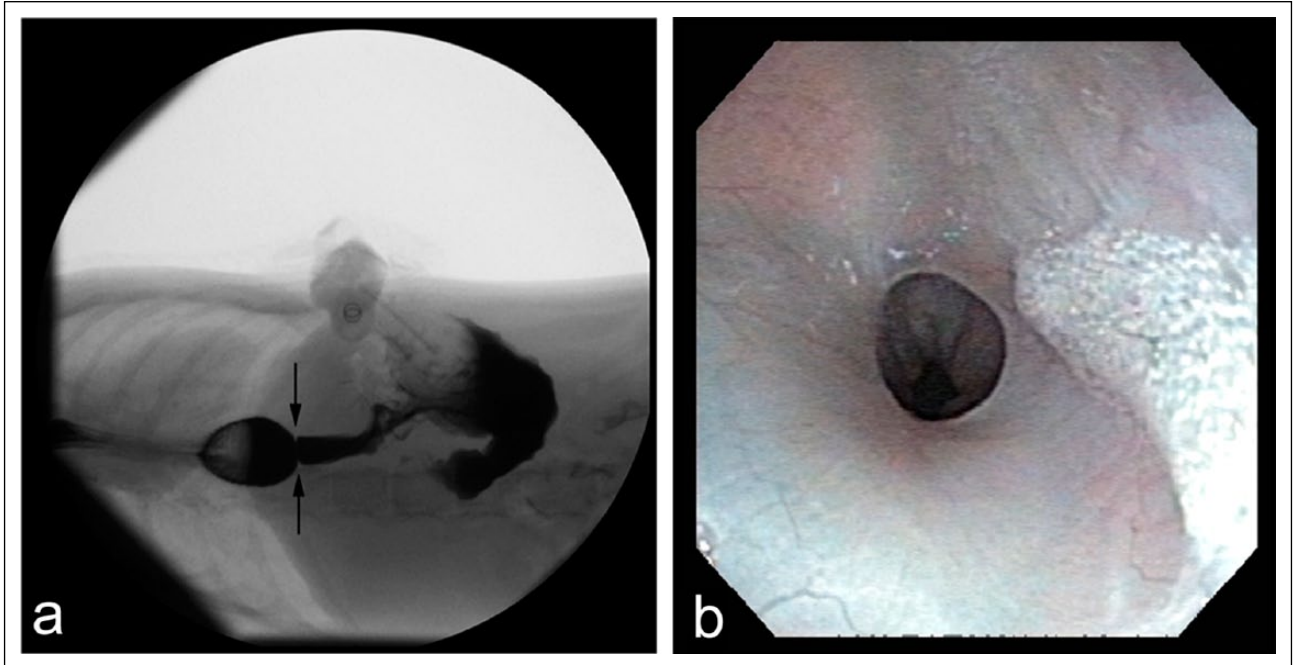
Ventrodorsal horizontal beam radiograph taken during the swallowing of liquid barium on day 45 after presentation. (a) Note the presence of focal narrowing (constriction) of the esophageal lumen and the level of the lower esophageal sphincter (arrows) and presence of a gastrostomy tube. (b) Endoscopic appearance of the esophageal stricture after 60 days of esophageal rest and gain of 1.73 kg body weight
